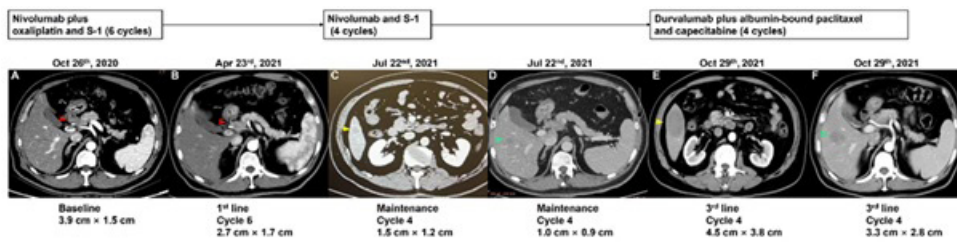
CT scans of metastasis at different stages during treatment. (A) showed the baseline of tumor before treatment. (B) manifested the change of nodule after 6-cycles nivolumab plus SOX. (C) to (D) manifested two new metastases on liver (marked by green arrow and yellow arrow) after 4-cycles of maintenance therapy, nivolumab and S-1. (E) to (F) manifested the enlarged liver metastases after 4-cycles durvalumab in combination with albumin-bound paclitaxel and capecitabine.
